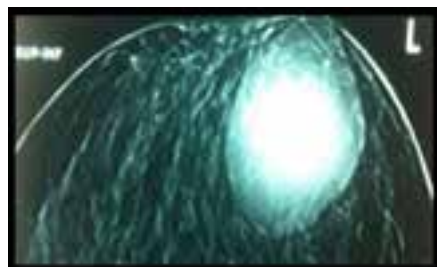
X-ray mammogram of the left breast shows a well delineated smooth walled dense breast mass – BI-RADS 3.
